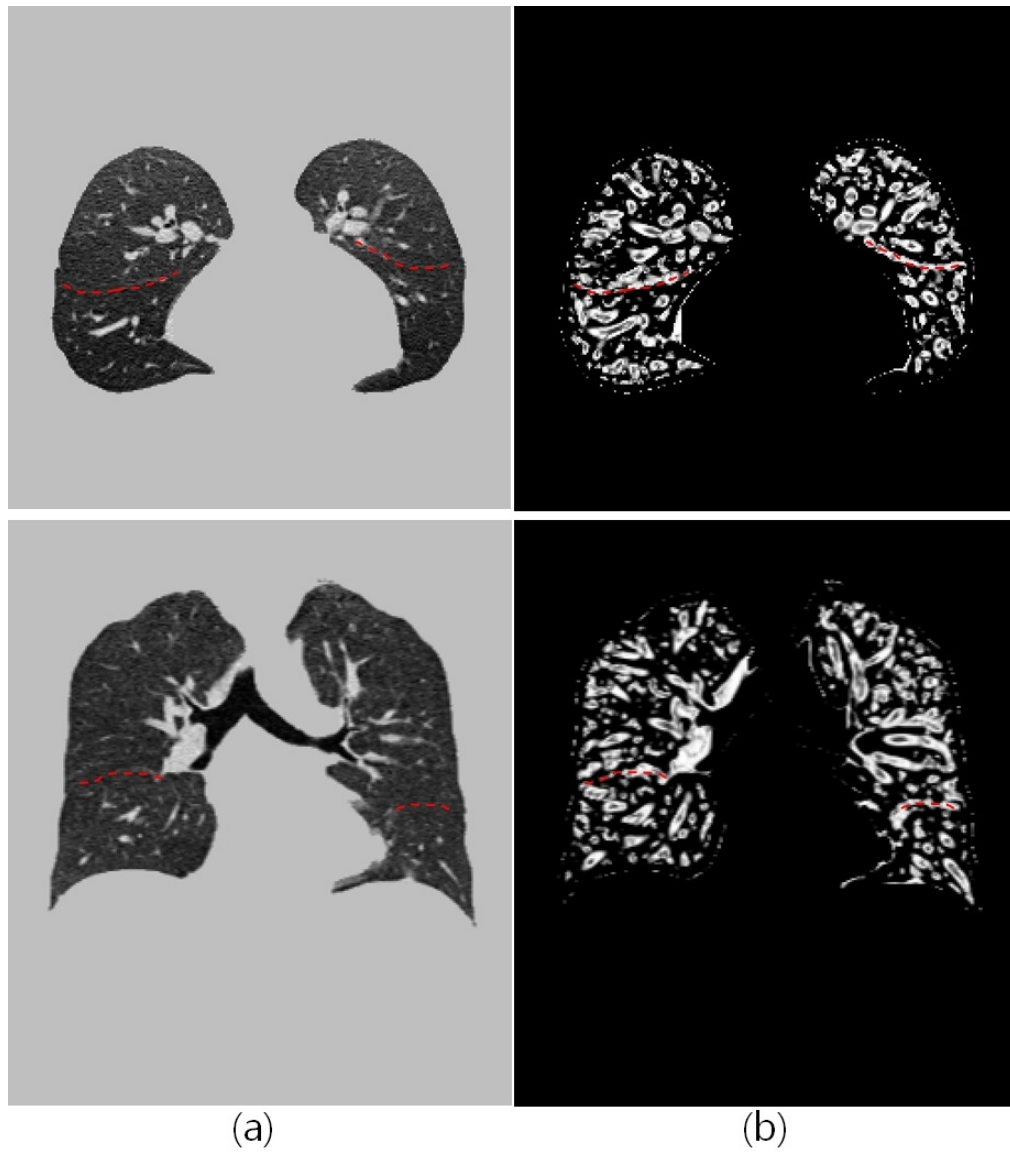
Extracted fissure-like structure in FRC. The upper row shows the transverse plane, and the lower row shows the coronal plane, (a) shows the corresponding CT image, and (b) shows the extracted fissure-like structure. The red dotted line represents the location of the fissure.
